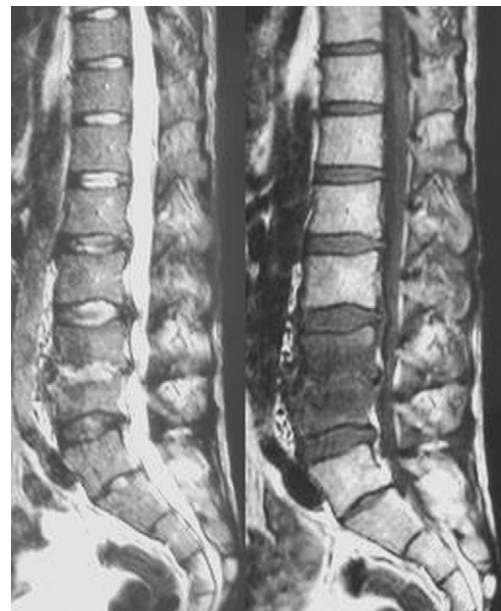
Magnetic resonance imagery, T1 and T2 weighted, showing the infectious process (patient 1).
